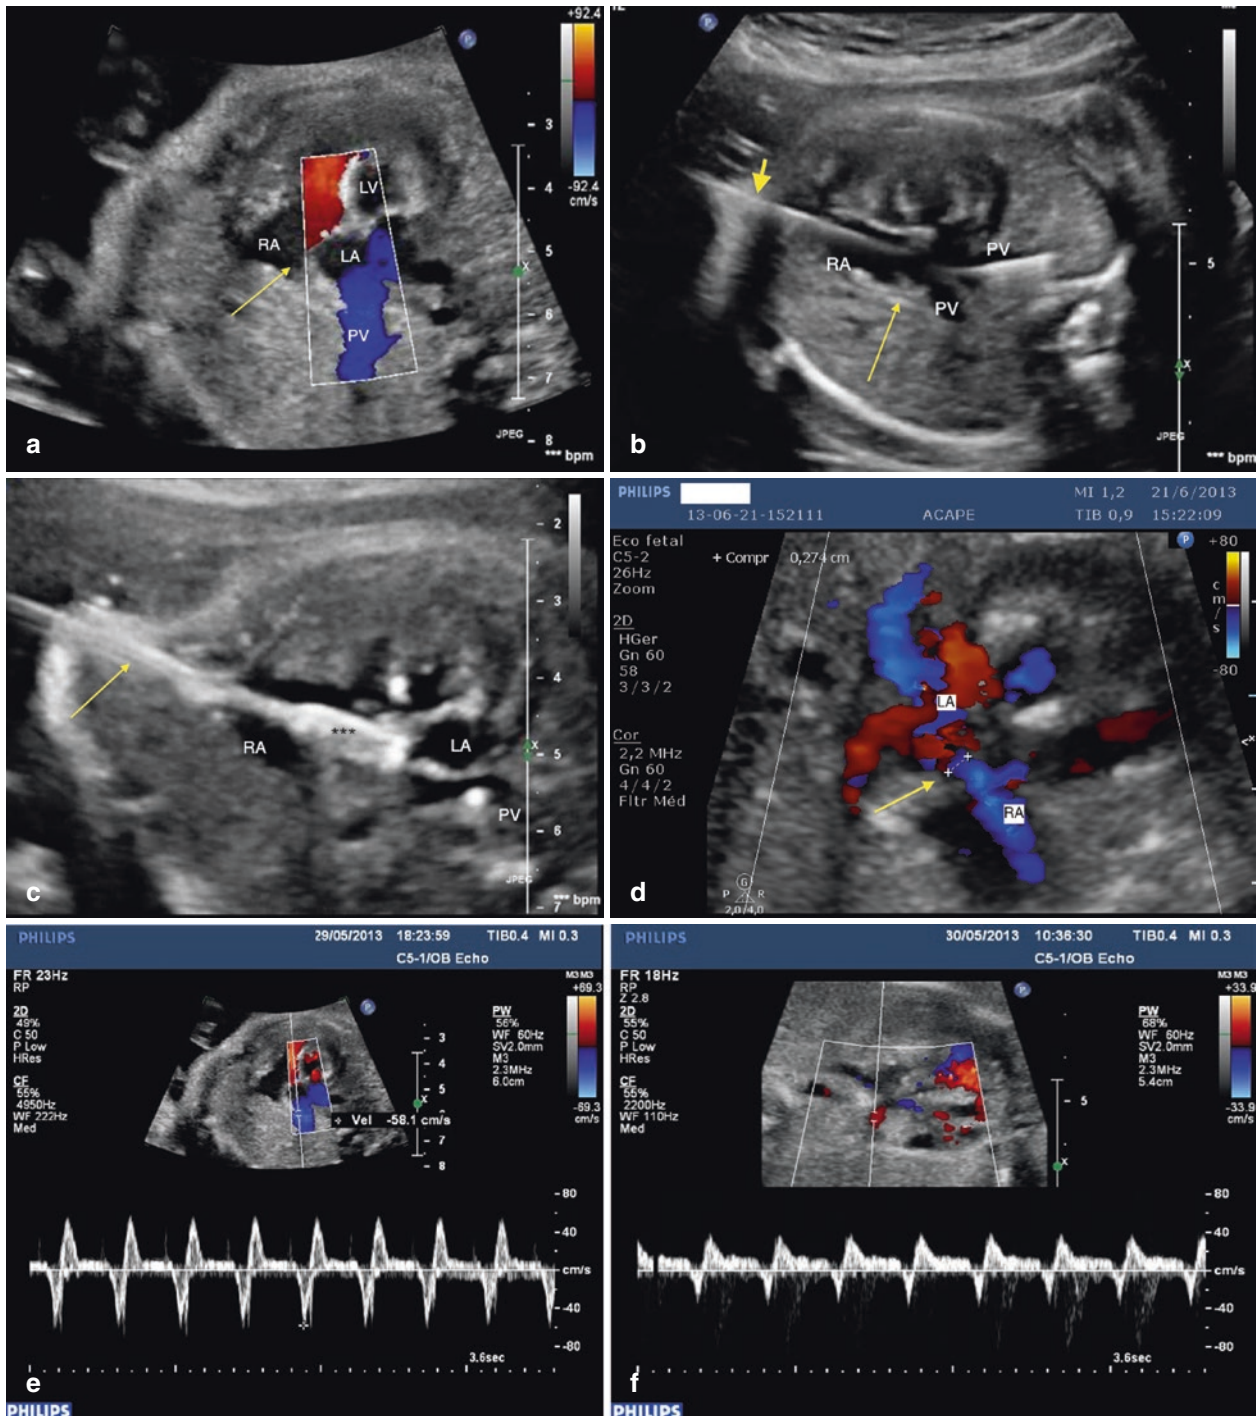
Fetal atrial septostomy in a 29 weeks gestational age fetus with established hypoplastic left heart syndrome. (a) Echocardiographic evaluation prior to the procedure. The interatrial septum (indicated by an arrow) is almost intact, and the LA is conspicuously dilated. Flow reversal in the pulmonary veins is detected by color flow mapping (blue color). The LV is small, and severe endocardial fibroelastosis can be seen as bright and diffuse hyperechogenic areas. (b) The interatrial septum (indicated by a long and narrow arrow) was traversed with the Chiba needle (indicated by a short and broad arrow), and the guidewire is seen in a pulmonary vein. (c) A 10-mm-long coronary balloon (marked with black asterisks) is inflated across the interatrial septum up to the burst pressure reaching 4.7 mm in diameter. The Chiba needle
